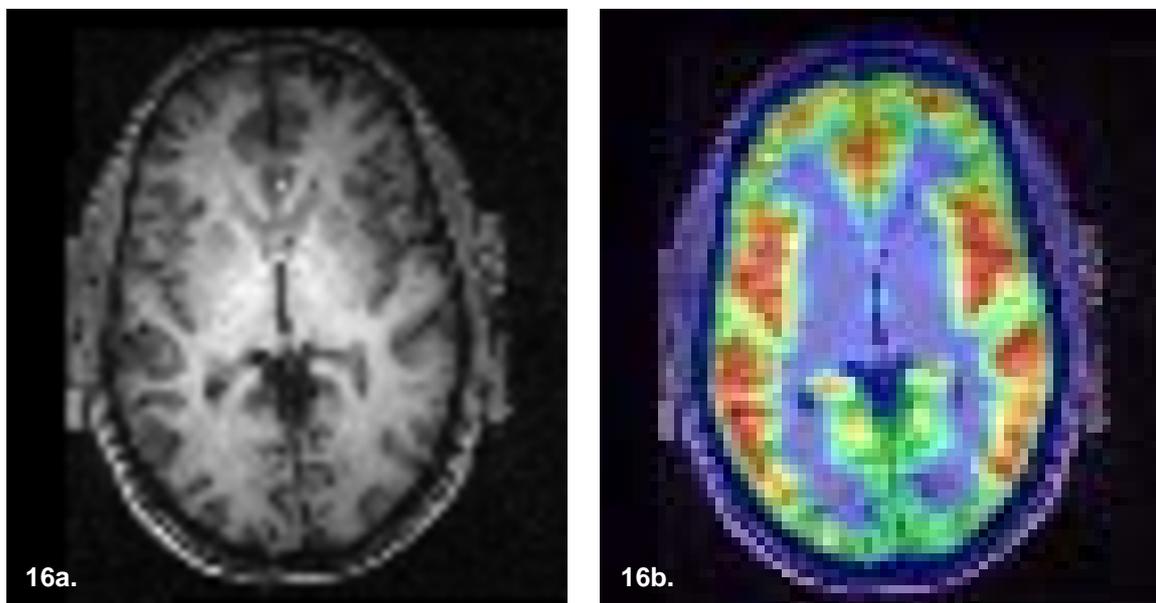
Co-registered MR image to PET<sub>ADD</sub> summation scan of a single subject
